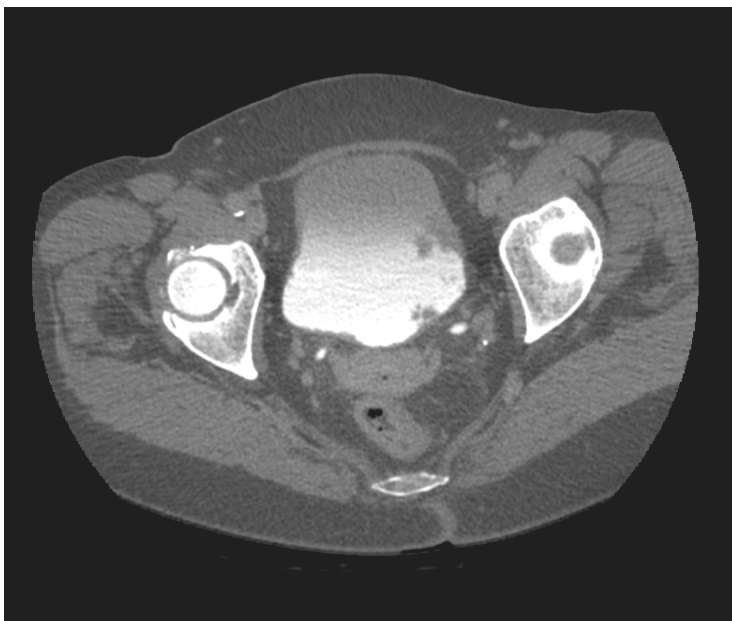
CT urography showing supine excretory-phase image acquired supine at 12.5 min post without exercising the patient.
